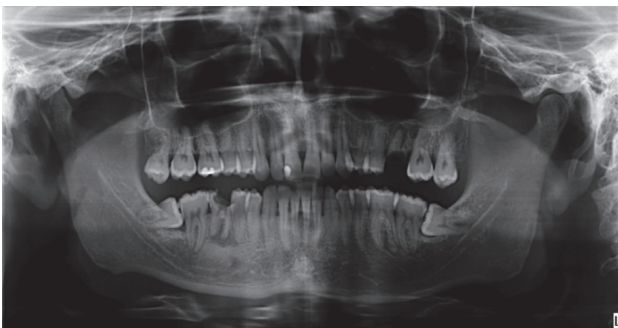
Panoramic radiograph showing the presence of root debris associated to apical radiolucent images in 2.6 and 4.6, in addition to the presence of the lower third molars retained in a horizontal position.
